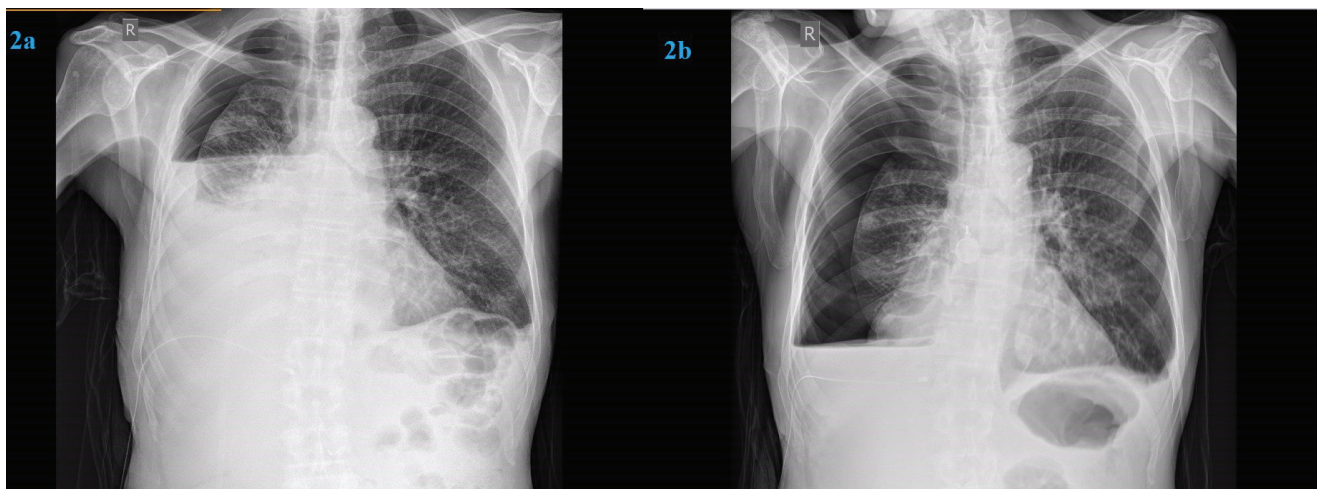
Post-drainage chest X-ray, 24 hours later, revealed a hydropneumothorax suspicious for a pneumothorax ex-vacuo (trapped lung) (2a). The chest tube was placed on suction without any additional re-expansion of the lung (2b)
